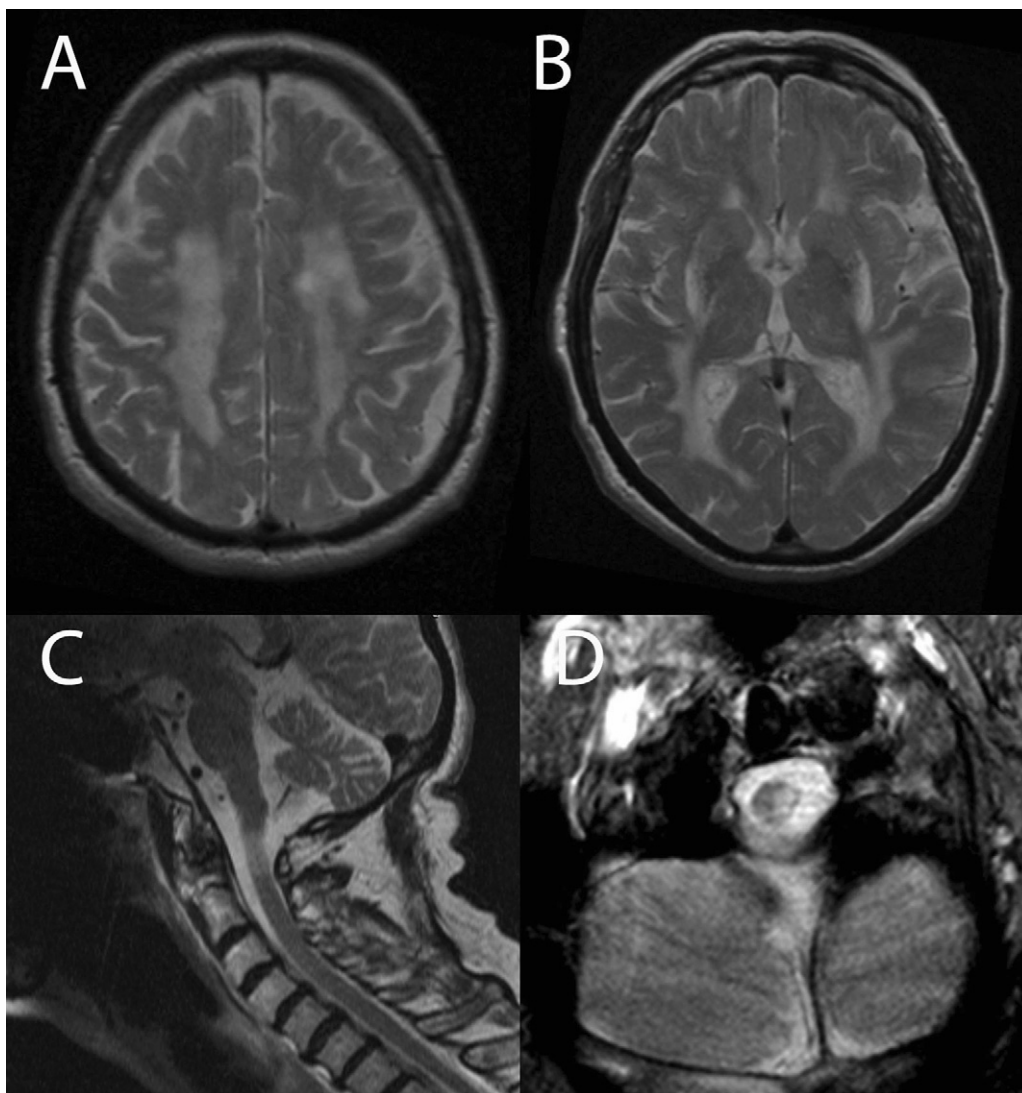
(A) Axial T2 weighted MR image at the level of the semioval center depicting well defined, ovoid shaped lesions in addition to confluent leucoencephalopathy. (B) Axial T2 weighted MR image at the level of the basal ganglia shows the “putaminal rim sign” consisting of a T2 prolongation secondary to astrogliosis of the lateral putamen. (C and D) Paramedian sagittal T2 weighted MR image of the craniocervical junction demonstrates a well defined hyperintense lesion of the medulla oblongata and adjacent cervical spinal cord which is confined to the left hemicord on the axial slice.
